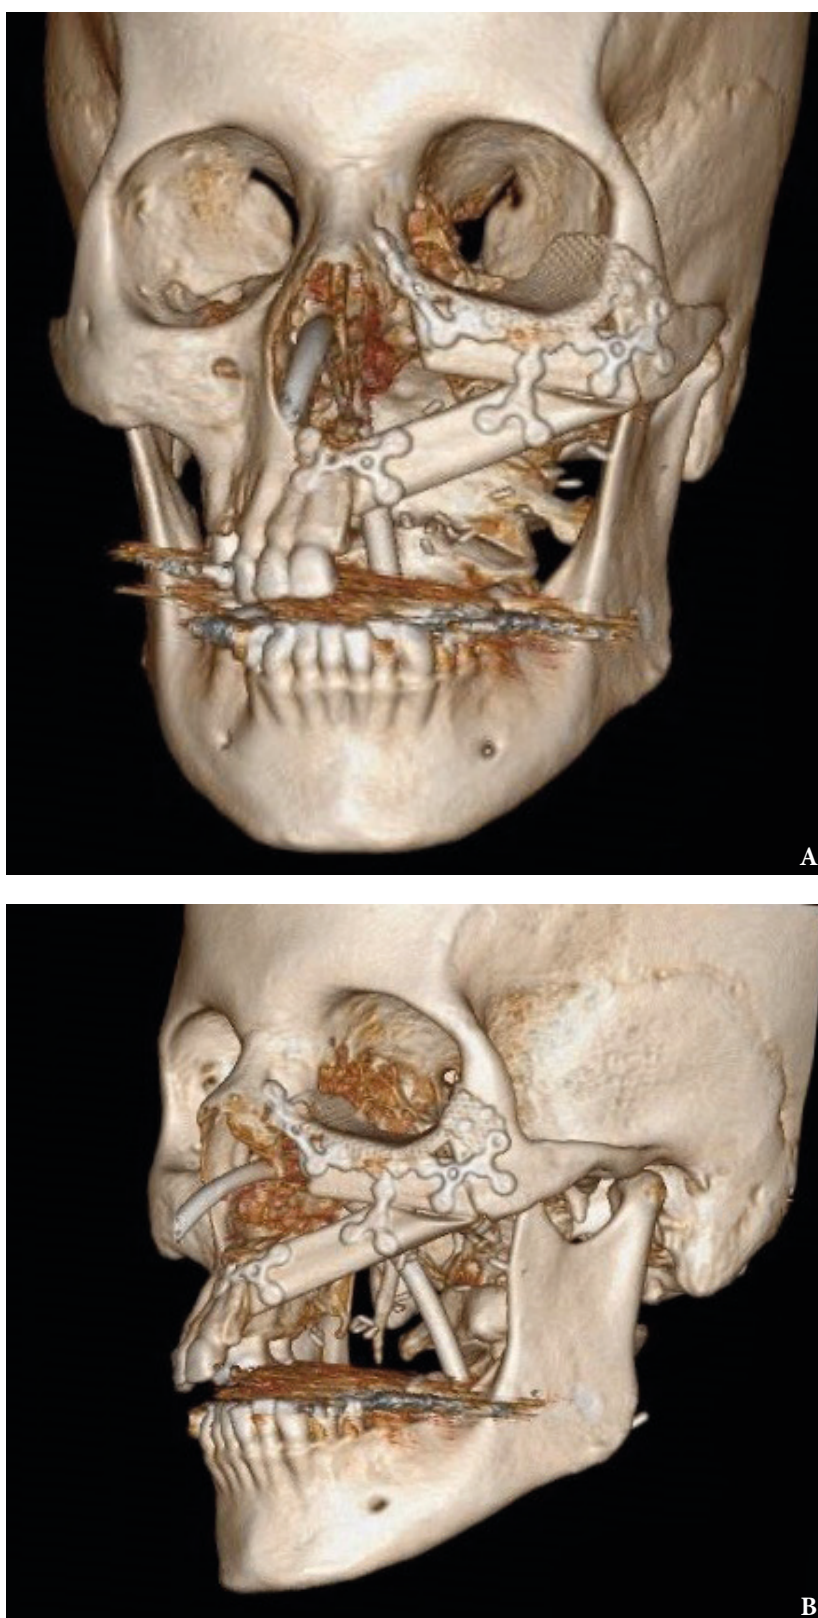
Post-operative three-dimensional computed tomography (A, B). Notes precise position of the osseous components of the chimeric transplant after reconstruction of Cordeiro type IIIA total left maxillectomy defect using virtual surgical planning. Printed with permission and copyrights retained by T.C.H.
